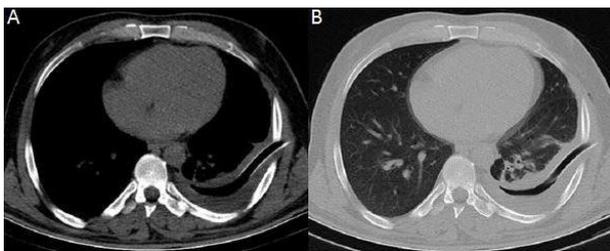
Axial section image of Thorax CT with 4 mm scan thickness without contrast material administration. (A) Mediastinum window and (B) Parenchyma window demonstrate the fluid collection with intensive contents between visceral and parietal pleura leaves and the extending drainage catheter at posterior basis of the left hemithorax
